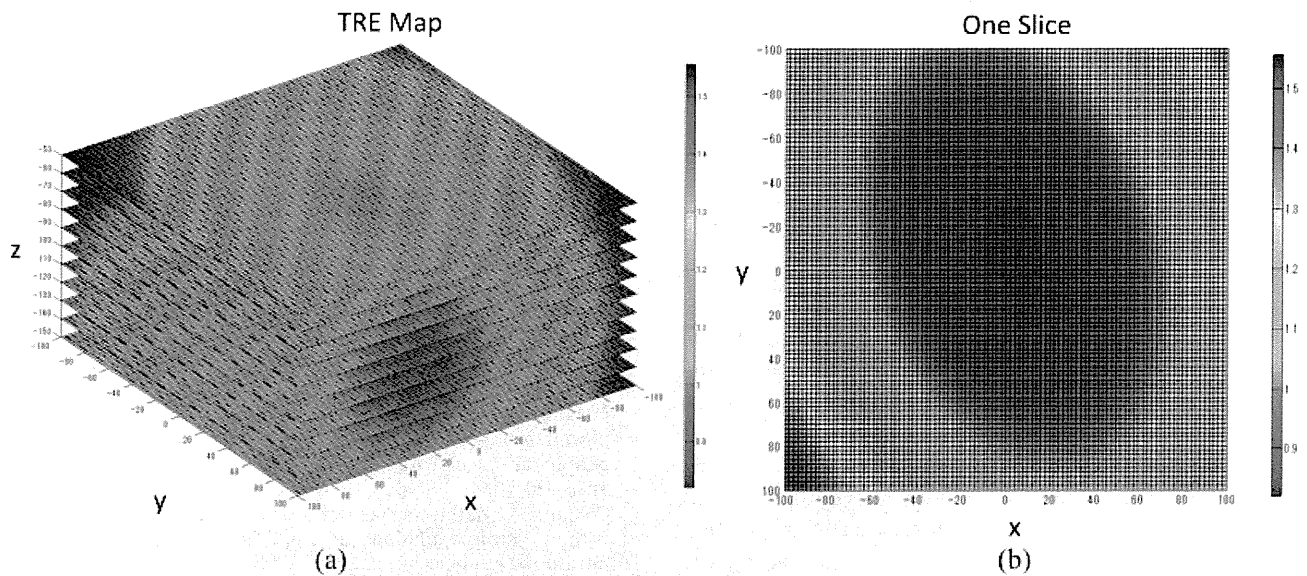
TRE map. The TRE map shows the RMS error of a target point when mapped through the estimated transformation matrix from the EM tracker frame to the CT image space. (a) Slices of the TRE map along the z-direction of the EM tracker frame. (b) One slice of the TRE map. The RMS error is demonstrated by the color from blue (0.8 mm) to red (1.6 mm). The configuration of the skin markers was designed so that the surgical site was located in the blue area
